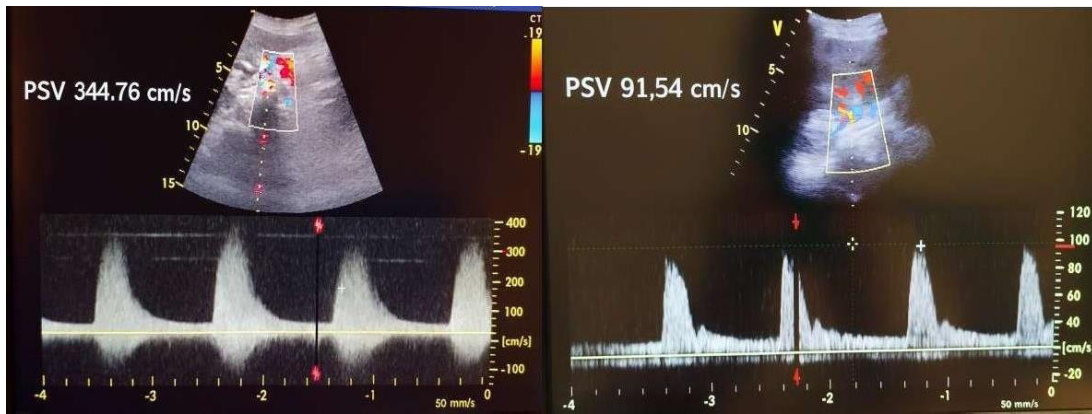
Doppler pathological flow with a hemodynamically significant stenosis of the right renal artery (on the left) and normalized flow after correction of the renal stenosis (on the right).
